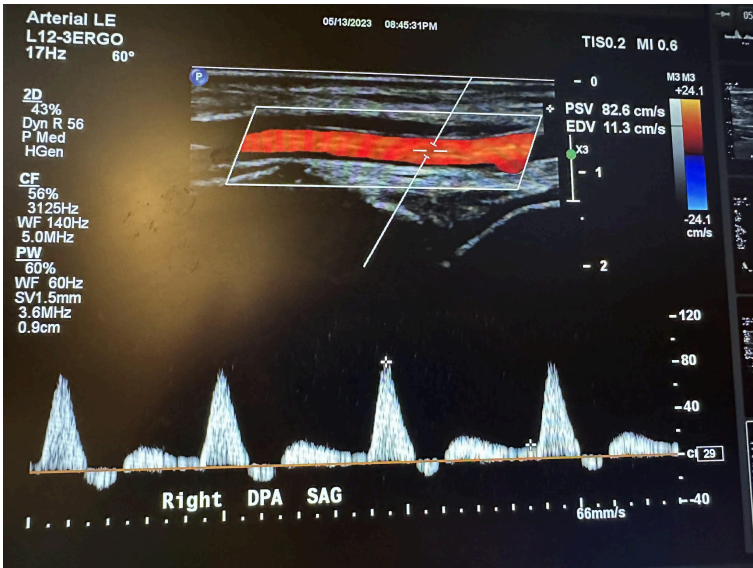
Sagittal image of the right dorsalis pedis artery with color Doppler and waveform analysis.
